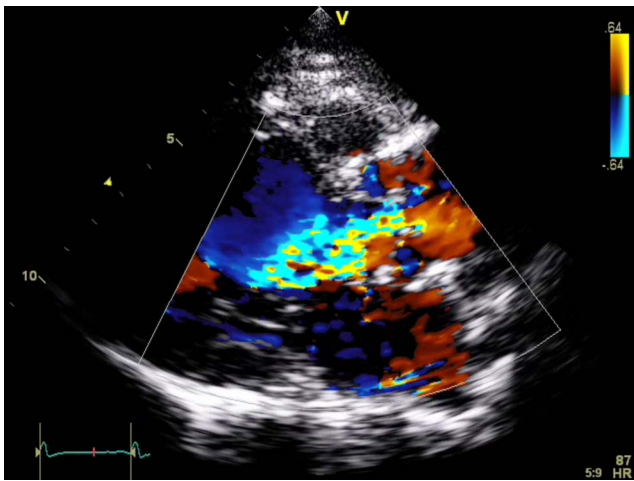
Echocardiographic image, left parasternal long-axis view with colour Doppler showing aortic regurgitation.
